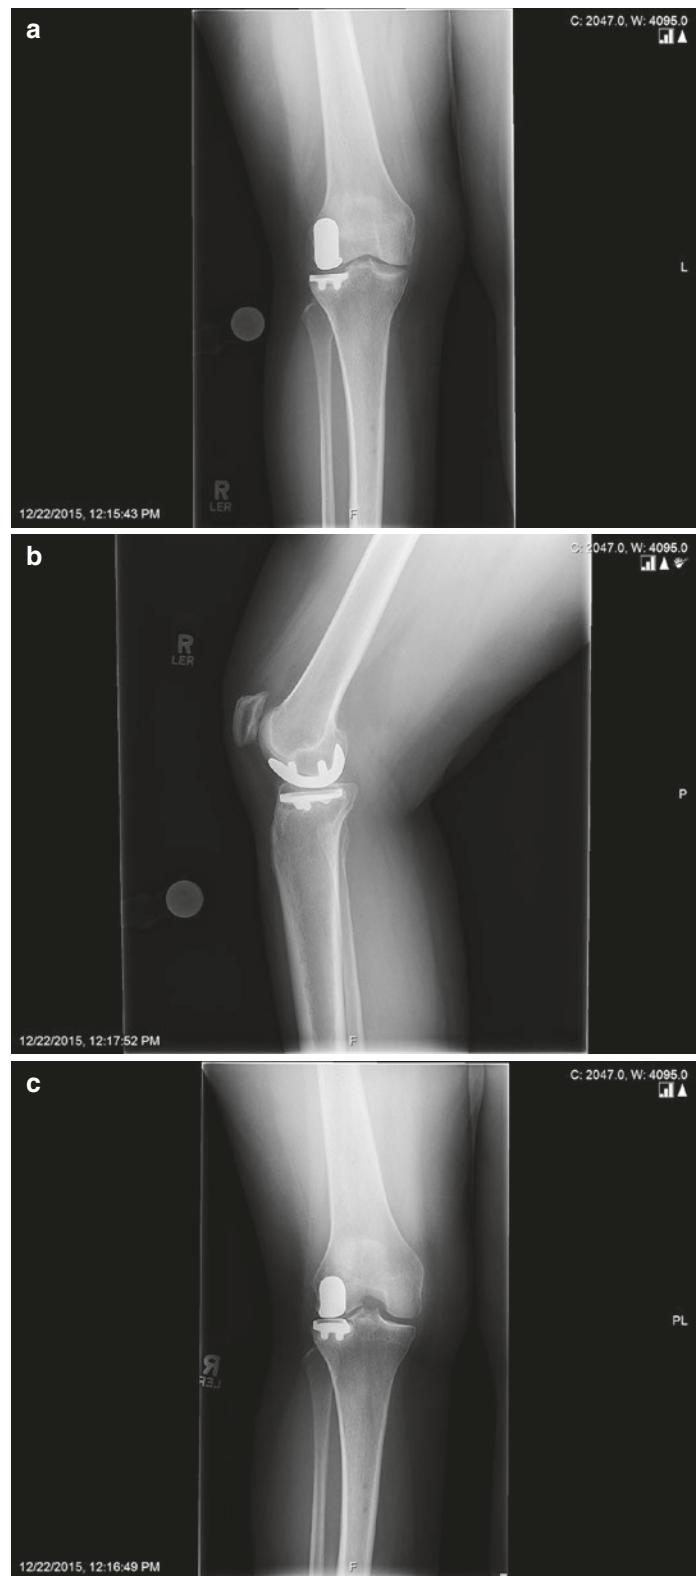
X-ray shows lucent lines around the tibia
